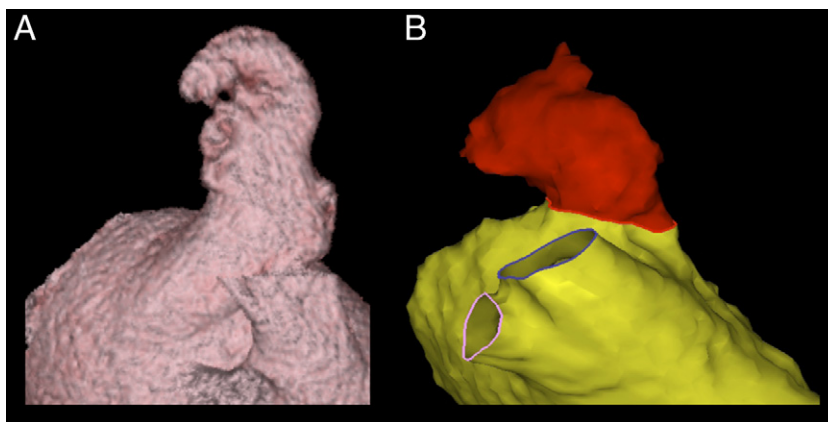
CT and MRI Scans of a Windsock LAA Morphology
